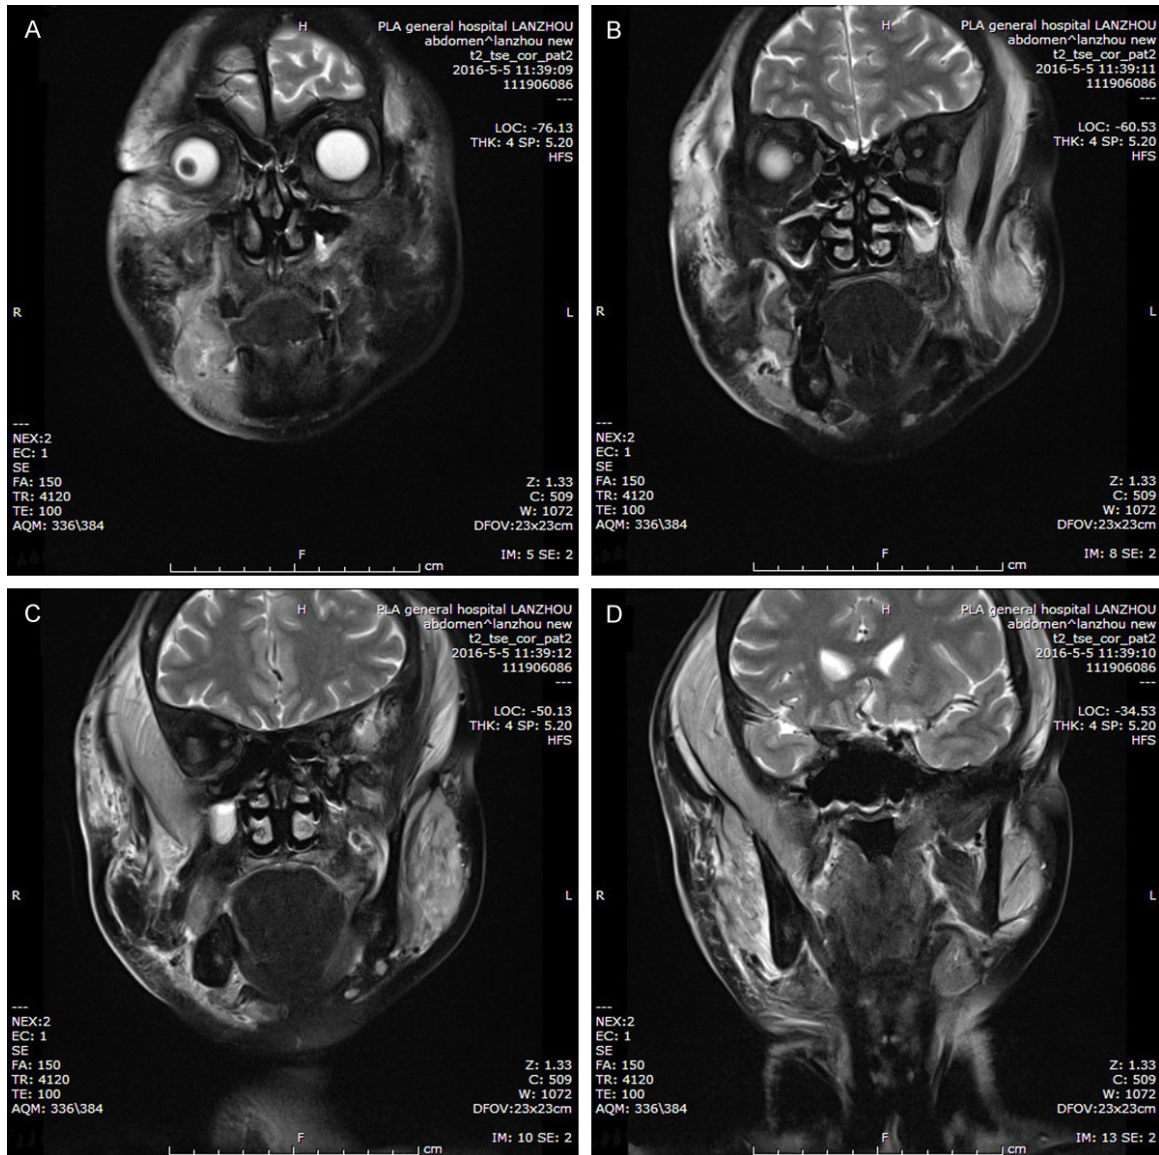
MRI before treatment, with abnormal signals around the musculus temporalis and masseter muscle on the right side, suggesting inflammatory exudation. A. Swelling subcutaneous soft tissue of the maxillofacial region with fat exudates, mainly on the right side. B and C. Bilateral abnormal signals around the swelling masseter and temporal muscles, with the change on the right more significant than the left. D. Moderately enhanced multiple lymphonodus in the bilateral carotid sheath.
